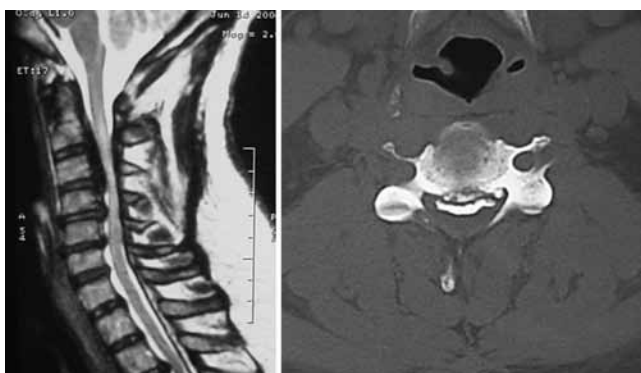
Images obtained in a 43-year-old woman of Mexican Pima Indian descent with severe cervical stenosis presenting with signs and symptoms of myelopathy. Sagittal MR imaging (left) demonstrates mixed type OPLL, with confirmation of ossified masses on an axial CT scan (right).
